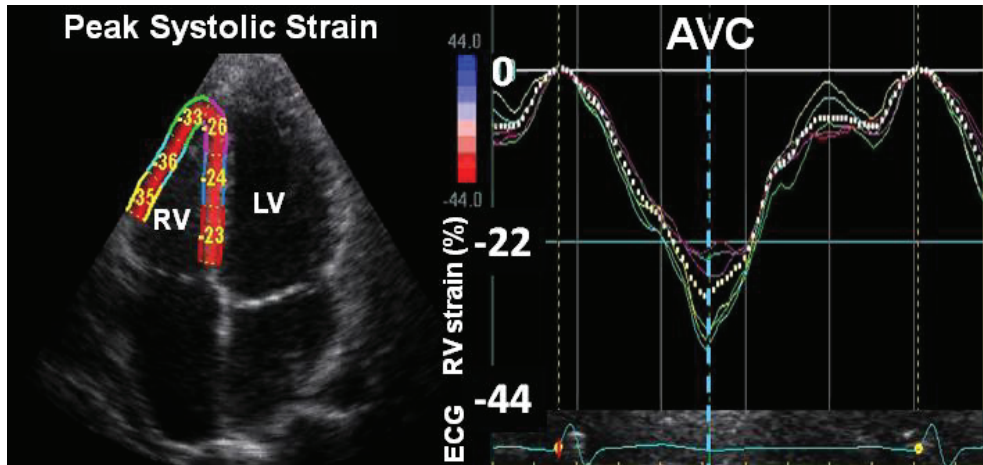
Left panel demonstrate apical 4-chamber view with the RV myocardium as region of interest in a healthy individual. Corresponding longitudinal strain curves are shown in the right panel.
